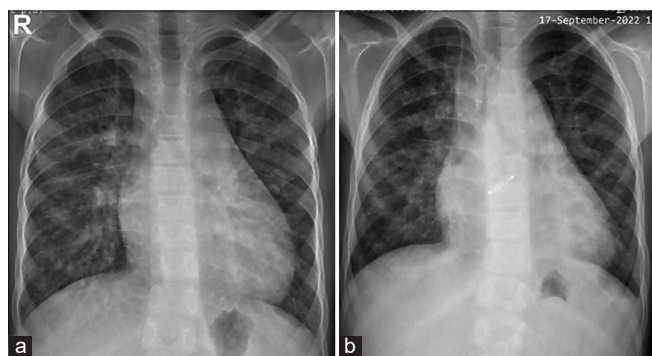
Frontal chest radiograph: Pre-operative (a) showing cardiomegaly with pulmonary plethora indicating an intracardiac left to right shunt, post-operative (b) showing the prosthetic aortic valve.
